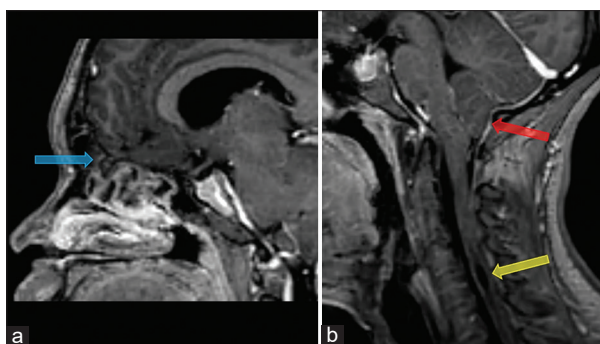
Sagittal 3D T1-weighted images (a) showing herniated dural sac through the left cribriform plate (blue arrow) and (b) small posterior fossa with cerebellar herniation (red arrow) and cervical cord syrinx (yellow arrow)
